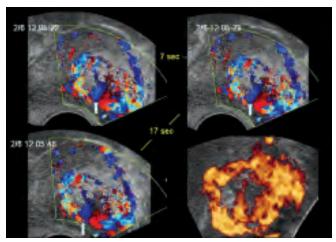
Three static color Doppler and power Doppler images were recorded in a complete hydatidiform mole. Color Doppler images were almost identical in spite of time differences, i.e. particular blood flow existed in the uterus. Red and blue color images suggested blood streams taking opposite directions, i.e. arterial jet stream into intervesicular spaces and venous drainage. Multiple small round images in the images can be molar vesicles. Power Doppler also showed rich intrauterine blood flow. The blue color flow (arrows) beated about 80 times per minute in the real-time color images. These findings are new diagnostic marker of complete hydatidiform mole *Courtesy:* G Varga
